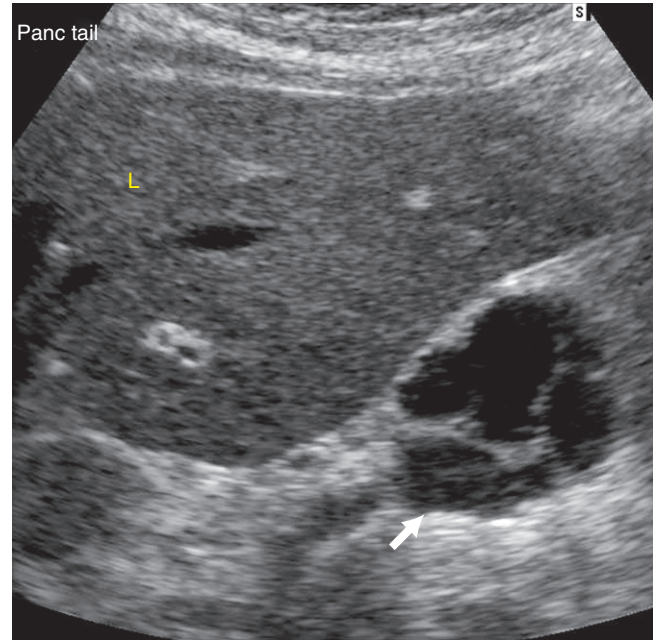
Another sonogram showing similar findings of a multi-septated cystic pancreatic mass (arrow). (L=liver.)
